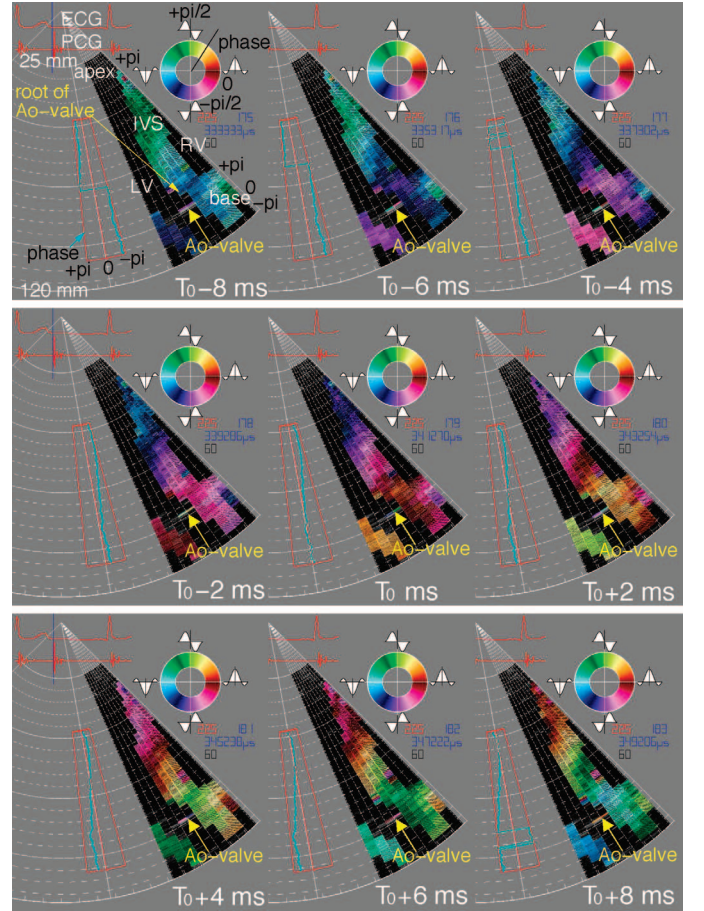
For the data in Fig. 4, the spatial distributions in the apical view of color-coded phase values for the 60-Hz component of the measured wavelets consecutively from $T_0 - 8$ ms to $T_0 + 8$ ms around the time of AVC (T_0). The blue line in the left-hand side of each figure shows the instantaneous phase $\theta(x; t)$ along the 4th ultrasonic beam. The phase jump is not unwrapped. The supplemental animation  shows the distribution of the phase values for 60-Hz component in the apical view for subject A. Each figure around the time of AVC (T_0) is shown here.
